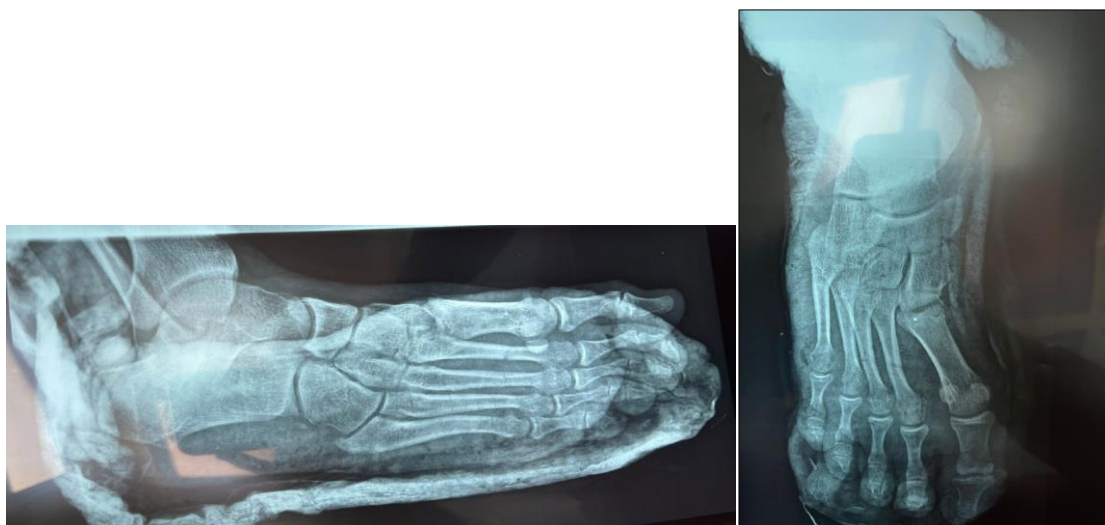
Radiography of the foot after reduction and immobilization
